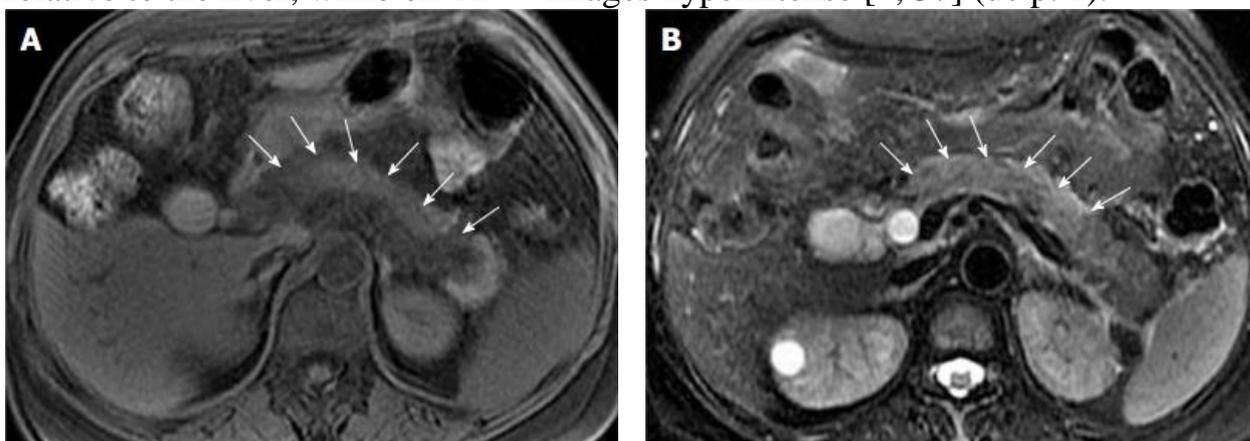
29-year-old s a man with acute edematous pancreatitis. T1-weighted imaging th e without contrast I (A) and T2-weighted sequence without opacification demonstrate that the head, body and tail part of the gland hypointense on the first picture and the second hyperintensity in comparison with liver — indicated by white arrows.
